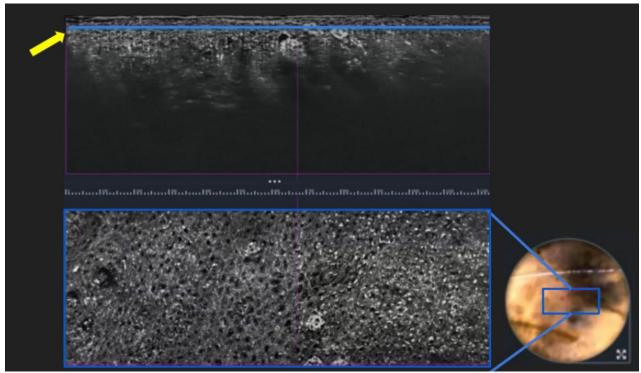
Suspicious skin lesion as seen by LC OCT. Similar to ultrasound, the "light" penetrates the skin demonstrating cellular resolution. The lower right shows the "transducer" location orientation on lesion with the blue square representing the volume imaged. The blue line on the upper longitudinal "coronal" plane image represents the lower cross sectional ("axial") view.
